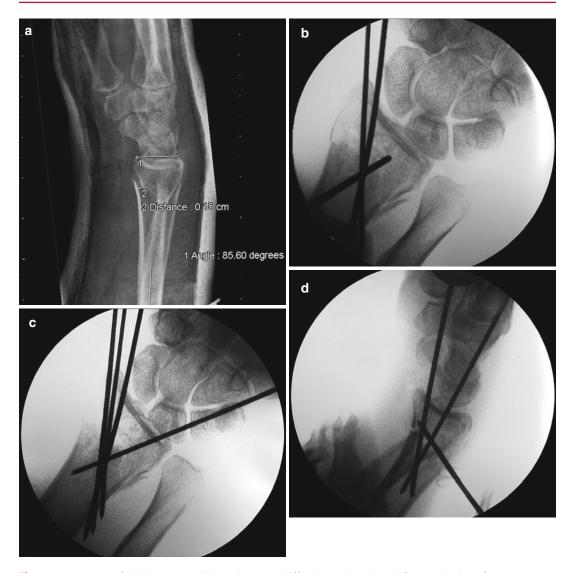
(a) X-ray of elderly woman with a volar cortex difficult to reduce closed. (b) Introduction of a percutaneous dorsal pin as a lever arm for the volar cortex. (c) Transfixation of the fracture. (d) Postoperative control x-rays
